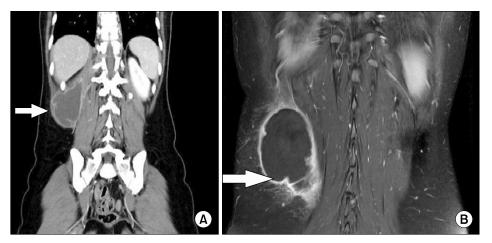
(A) Preoperative CT: Showing large cystic lesion with thick enhancing wall with infiltration into adjacent tissue, extending in between right latissimus dorsi and erector spinae, involving iliopsoas muscle and posterior pararenal space of cold abscess. (B) Preoperative MRI: Showing TB spondylitis at T9~T12 with adjacent paravertebral abscess with huge cold abscess.
